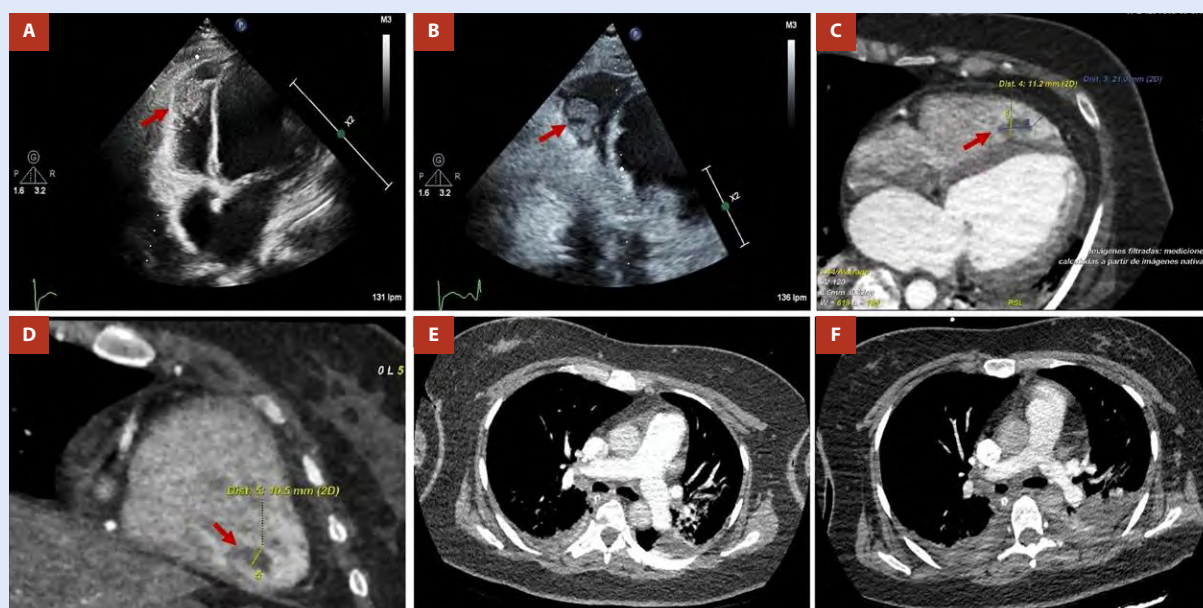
Multimodality imaging demonstrates an isolated right ventricular thrombus and excludes pulmonary embolism. A–B. Transthoracic echocardiography, parasternal long-axis (A) and parasternal short-axis mid-ventricular views (B), demonstrating a mobile, echodense, RV intracavitary mass (red arrows) consistent with thrombus, anchored to the RV free-wall trabeculations. C–D. Cardiac computed tomography confirming a well-defined intraluminal thrombus within the RV cavity (red arrows), measuring 11 × 21 mm in orthogonal planes. The mass exhibits homogeneously low attenuation, sharply demarcated from the endocardial border, supporting the diagnosis of thrombus rather than tumor. E. Baseline CTPA, performed the same day as the echocardiographic identification of the RV thrombus, demonstrating patent pulmonary arteries without filling defects. F. Follow-up CTPA performed one week later, again showing no pulmonary artery thromboembolism.
